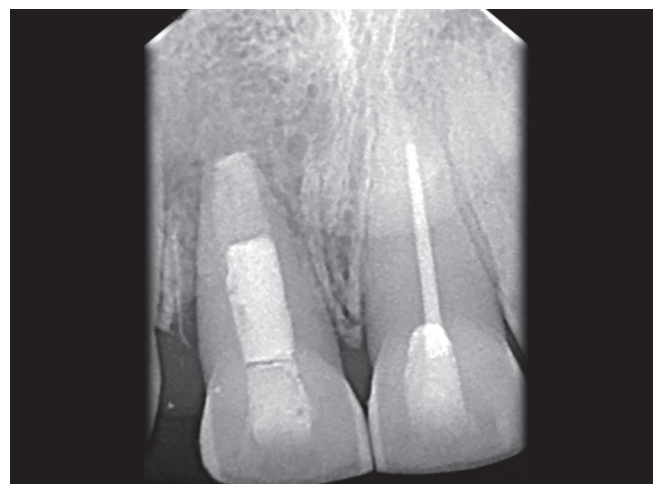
Three-month follow-up radiovisiograph showing healed periapical lesion
